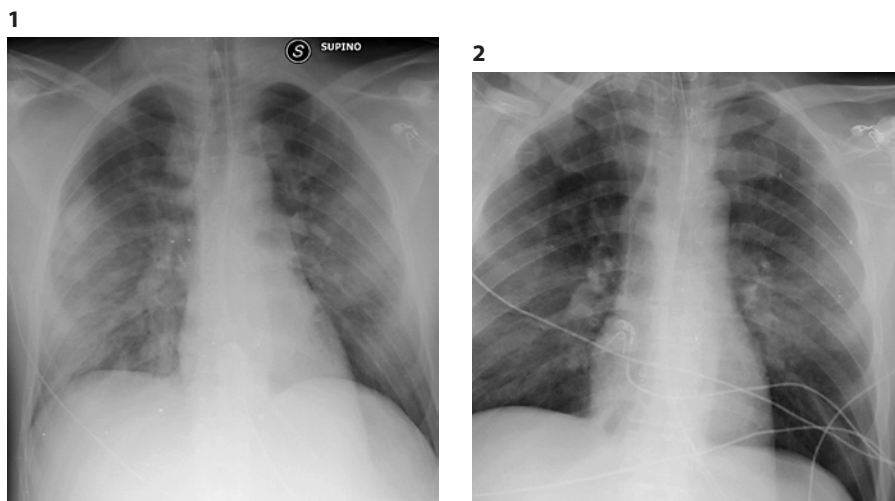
Admission CRX: bilateral multiple confluent opacities. CRX, chest radiograph.
